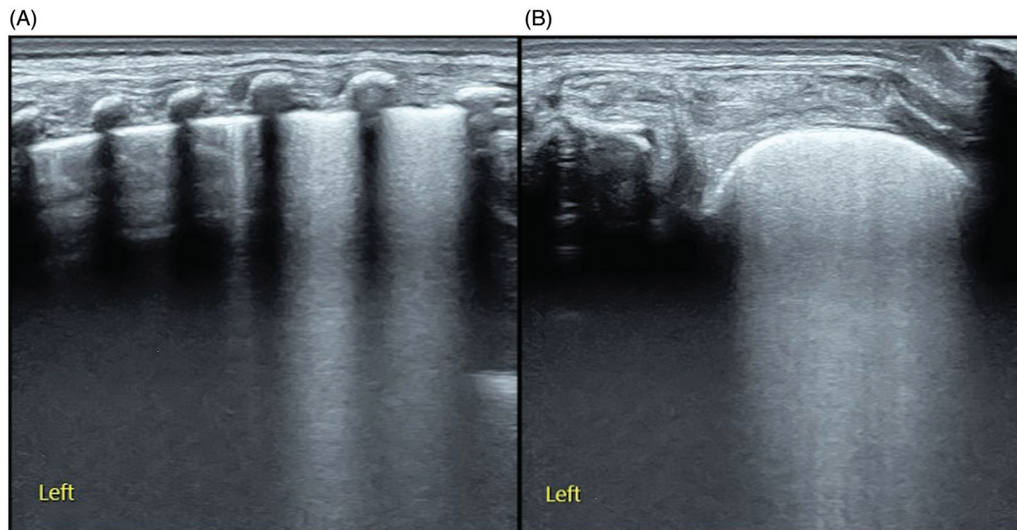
Transverse scanning help to diagnose Grade I RDS. A premature infant with progressive dyspnea and moaning was admitted to the hospital. (A) Longitudinal scanning indicates only mild lung edema, suggesting the wet lung's possibility. (B) Transverse scanning shows typical ground-glass opacity signs, which are typical ultrasound characteristic of Grade I RDS [35].
